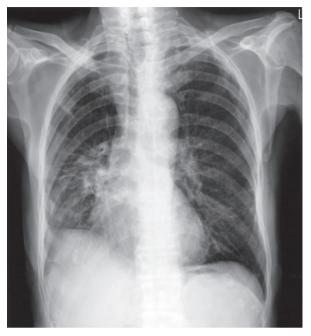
Chest radiograph showing improved right lower lung consolidation after steroid treatment.
